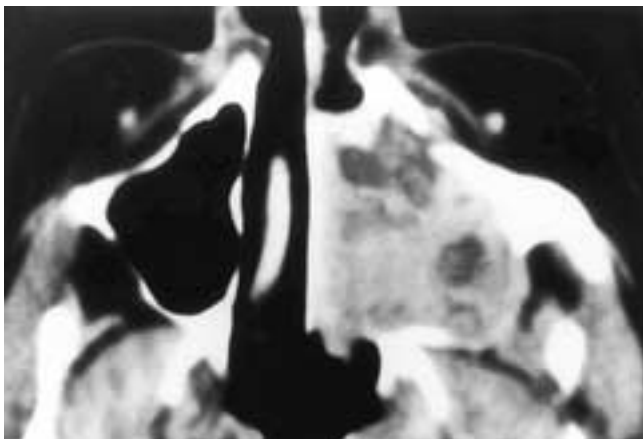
Axial CT scan shows a partially expansile, partially destructive, nonhomogeneous tumor in the left maxillary sinus. The lesion has extended into the nasal fossa and the infratemporal fossa. This patient had an adenoidcystic carcinoma.
